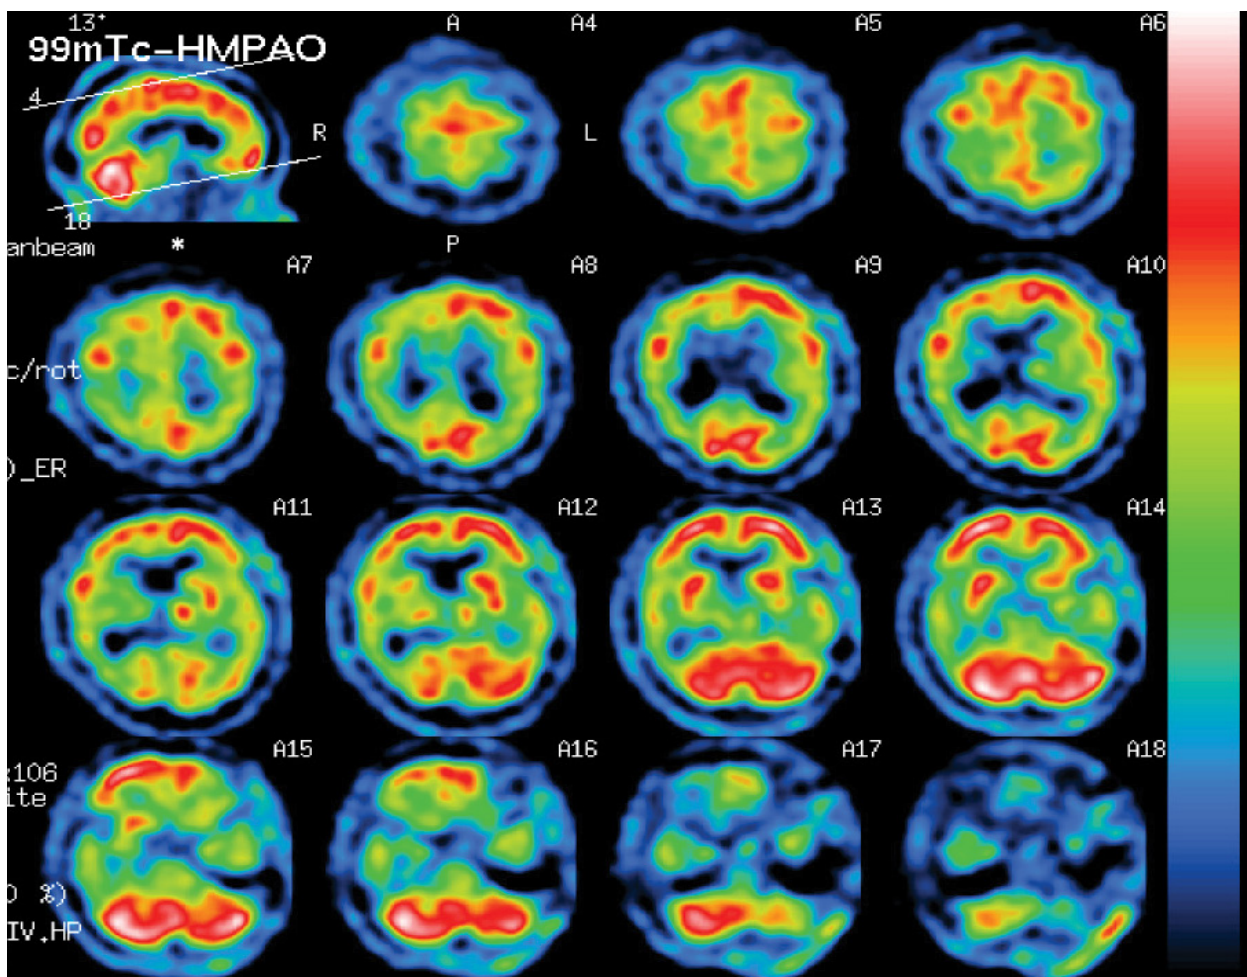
^{99m}Tc-HMPAO SPECT at 57 years old showed a decrease in the regional cerebral blood flow in the bilateral fronto-parieto-temporal lobes, more marked on the right than on the left.
